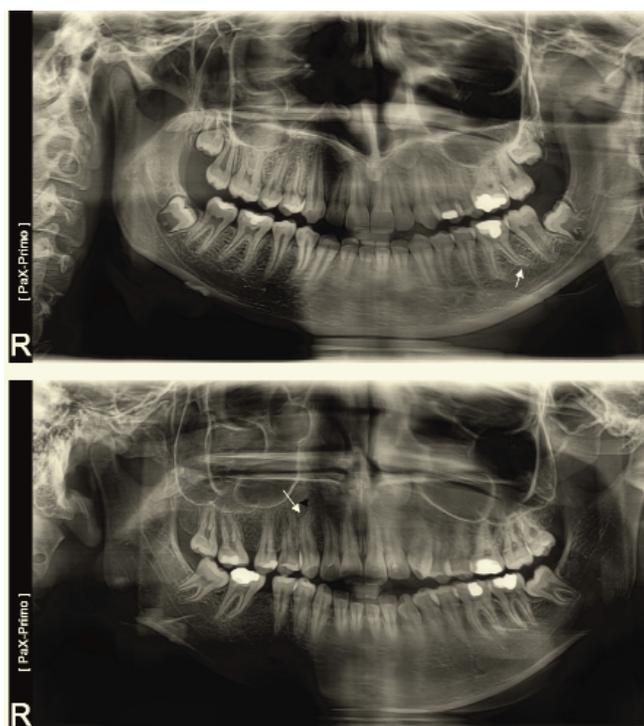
Examples of root dilacerations belonging to different tooth types on formed panoramic radiograph.
